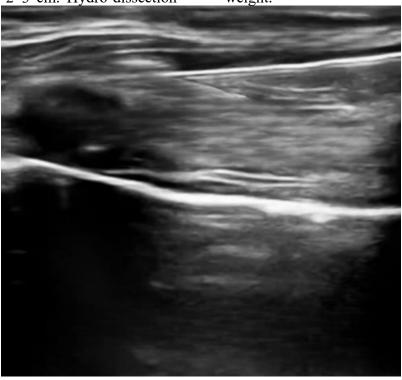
The ultrasound-guided SPIP block targets the fascial plane between the pectoralis major and external intercostal muscles. The needle is precisely guided under ultrasound to this interface for effective local anesthetic deposition.
